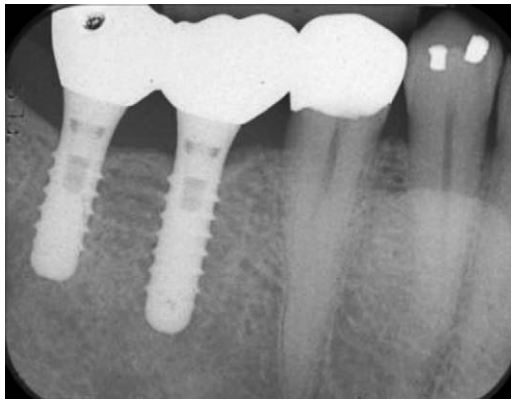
Periapical radiograph of two non-submerged (one-piece) dental implants placed in the posterior mandible. The final crowns are connected together. The crowns contact the tops of the implants approximately three millimeters above the alveolar crest. This means that the interface or microgap is located coronal to the bone level.
